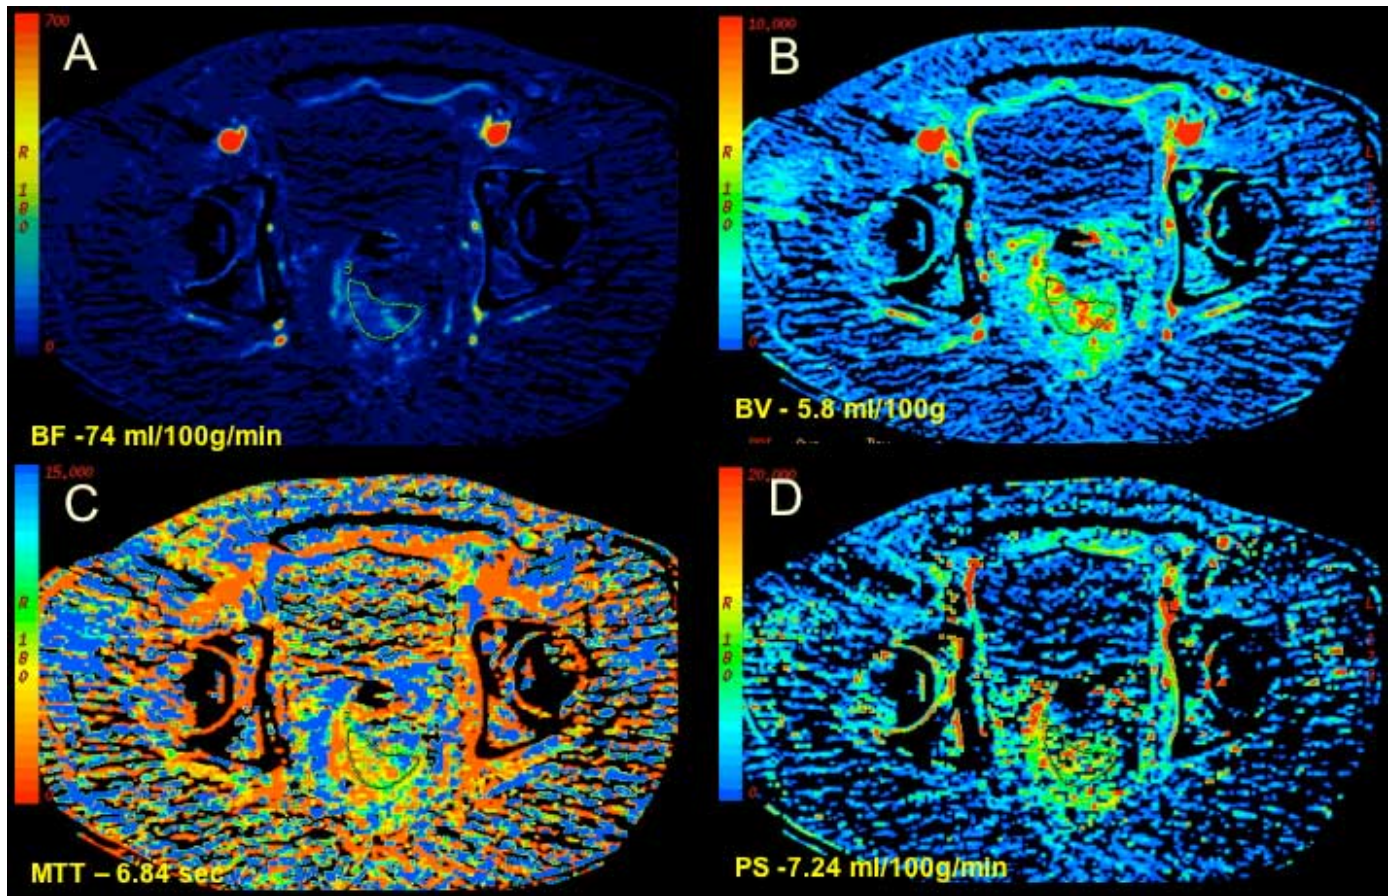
Perfusion CT (CTp) scans of the tumor shown in Figure 1. (A) Blood flow (mean, 74 ml/100 g/min); (B) Blood volume (mean, 5.8 ml/100 g); (C) mean transit time (MTT) (6.84 seconds); and (D) permeability-surface area product (mean, 7.24 ml/100 g/min).
